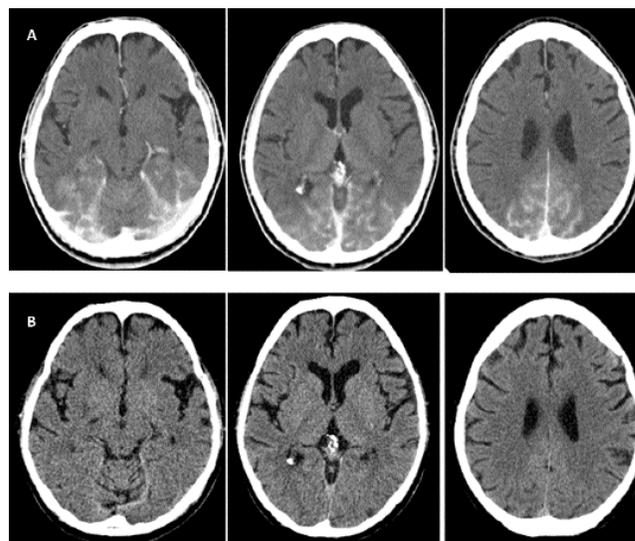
(A) Cranial computed tomographic scan done within 30 minutes after coronary angioplasty showed marked bilateral symmetrical subarachnoid hyperdensities in the posterior cerebral circulation area. (B) A repeat CT scan done after complete recovery of vision (72 hours) showed complete resolution of hyperdensities in the same vascular territory.
